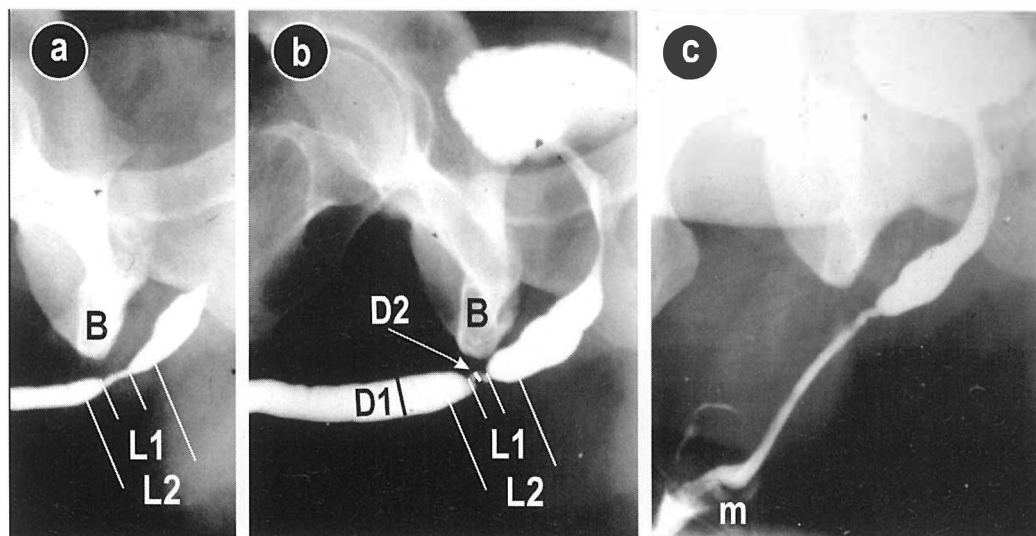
Radiographic urethrography(RUG)- evaluation of the stricture and measurements; a) Less contrast application, b) More contrast application, c) During voiding. B-bulbar stricture, L2-the length of the whole stricture, L1-the length of a tight stricture, D1-normal diameter, D2- reduced lumen, m- suspected meatal stricture.
